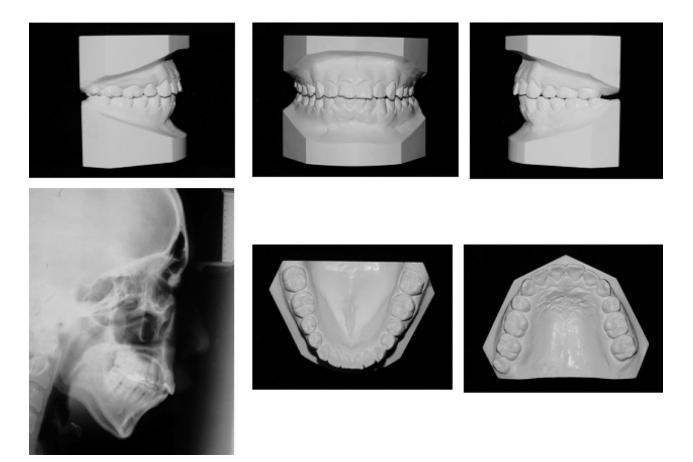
Six-month postretention study models and cephalometric radiograph.
